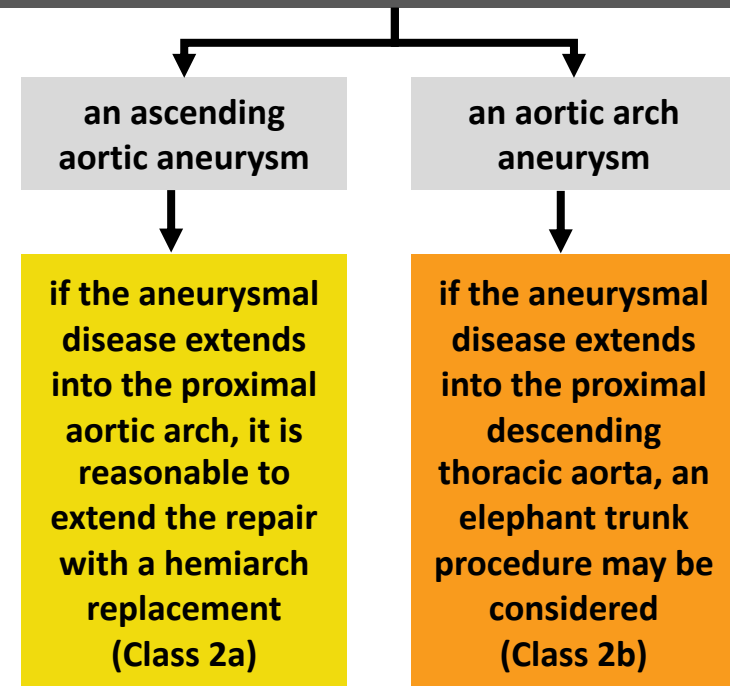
Abbreviations: AV indicates aortic valve; cm, centimeter; CT, computed tomography; y, year; MAT, multidisciplinary aortic team; max, maximal; pt, patient; SD, standard deviation; and y, year.
